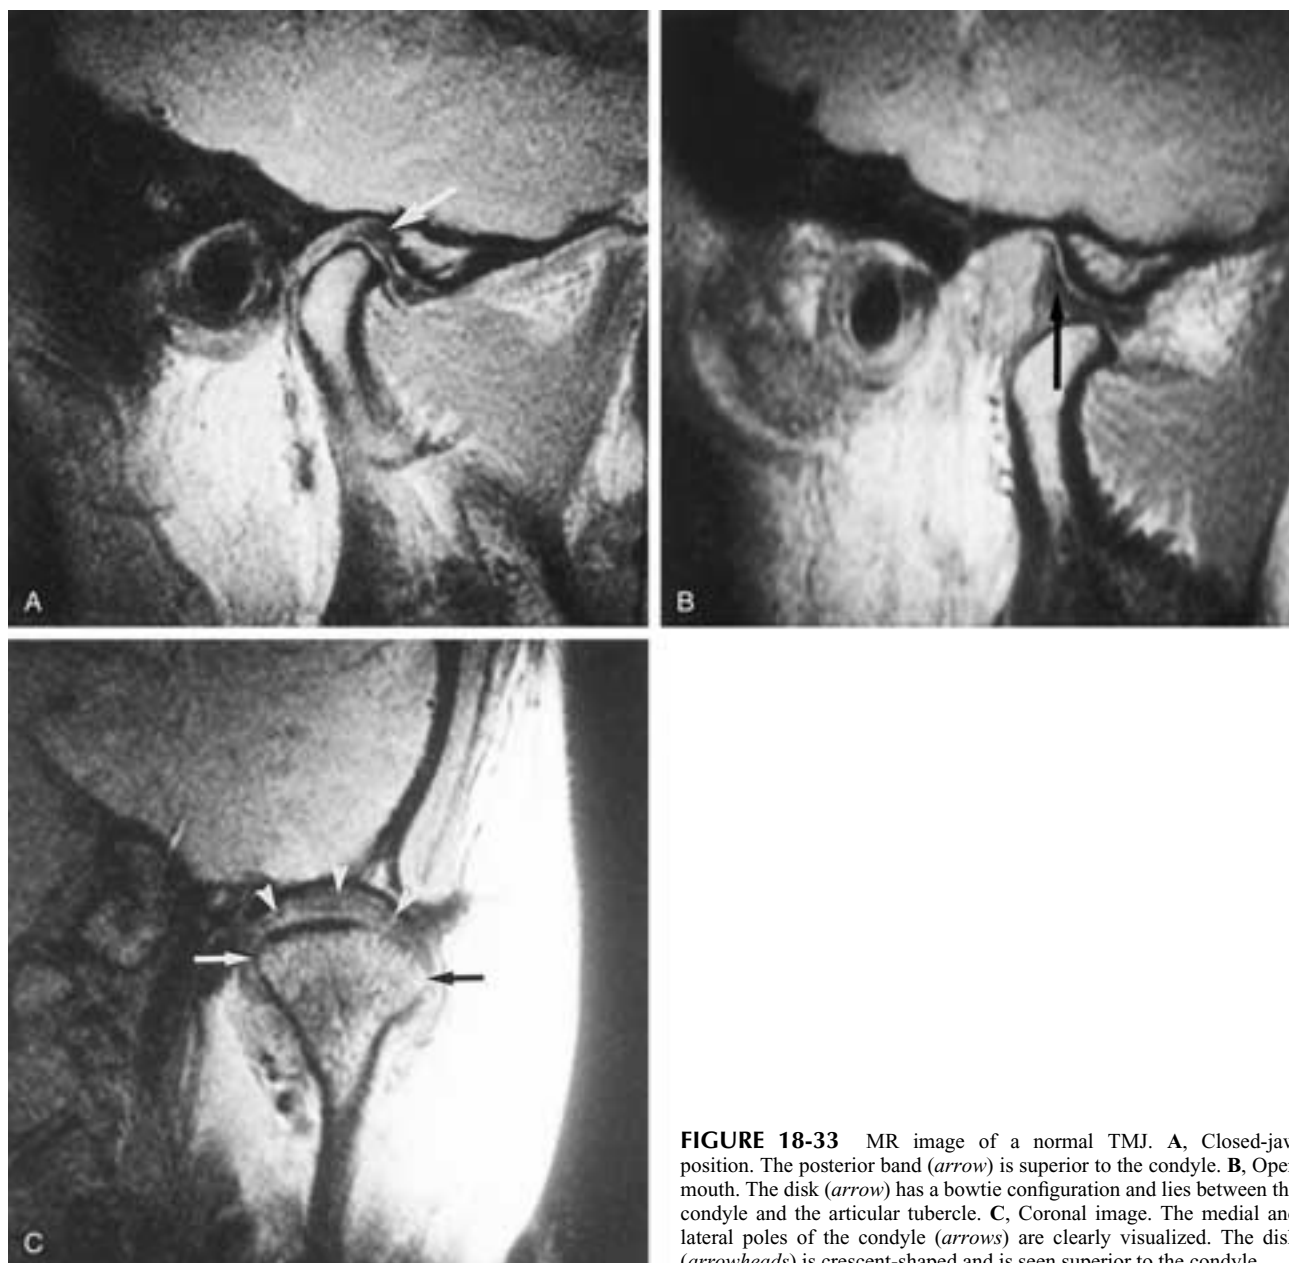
MR image of a normal TMJ. A, Closed-jaw position. The posterior band (*arrow*) is superior to the condyle. B, Open mouth. The disk (*arrow*) has a bowtie configuration and lies between the condyle and the articular tubercle. C, Coronal image. The medial and lateral poles of the condyle (*arrows*) are clearly visualized. The disk (*arrowheads*) is crescent-shaped and is seen superior to the condyle.
